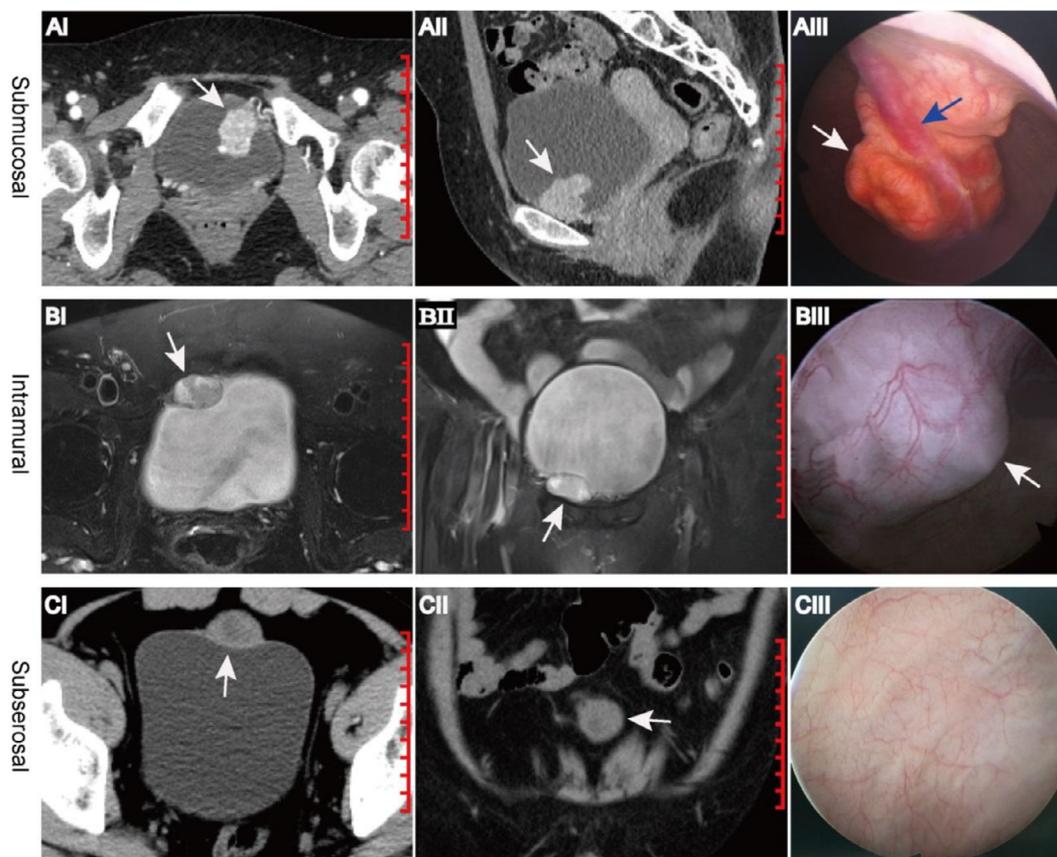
Imaging and cystoscopy of different anatomical types of PUBs. AI (axial contrast-enhanced CT) and AII (sagittal CT) demonstrate a solid irregular tumor protruding into the bladder cavity; AIII (cystoscopy) reveals a conspicuous hypervascular (blue arrow) nonpedunculated tumor covered with congestive mucosa. BI (axial MRI, T2WI) and BII (coronal MRI, T2WI) demonstrate a solid oval tumor protruding into both the bladder and pelvic cavities; BIII (cystoscopy) reveals a nonpedunculated tumor (intravesical portion) covered with normal mucosa, and the profile is less conspicuous than that of a submucosal PUB. CI (axial CT) and CII (coronal CT) demonstrate a solid globular tumor protruding into the pelvic cavity, whereas CIII (cystoscopy) reveals a normal bladder cavity.
